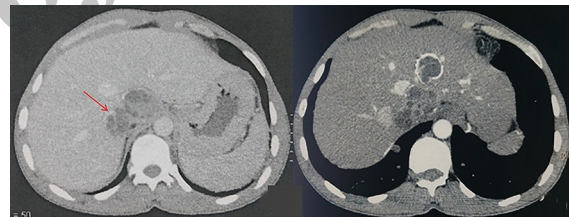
Axial CT section performed after intravenous injection of contrast agent confirms the findings of ultrasound. The hydatid cyst was opened in the retrohepatic vena cava and remained only passing sluices, which are enhanced after injection (arrow).
